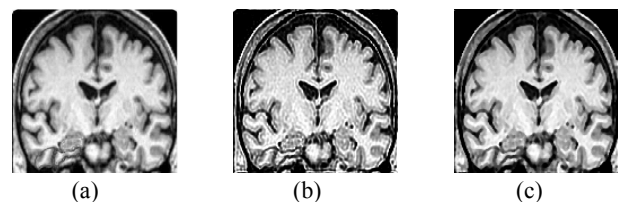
MRI Preprocessing (a) Original (b) Deblurred image (c) Smoothed image
